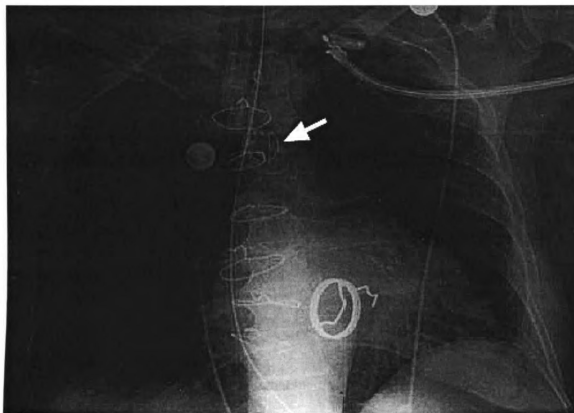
Chest radiograph of a patient with outlet strut fracture. The outlet strut has separated and is floating near the flange. The occluder disc (arrow) has embolized the aortic arch. Adapted from [81]
